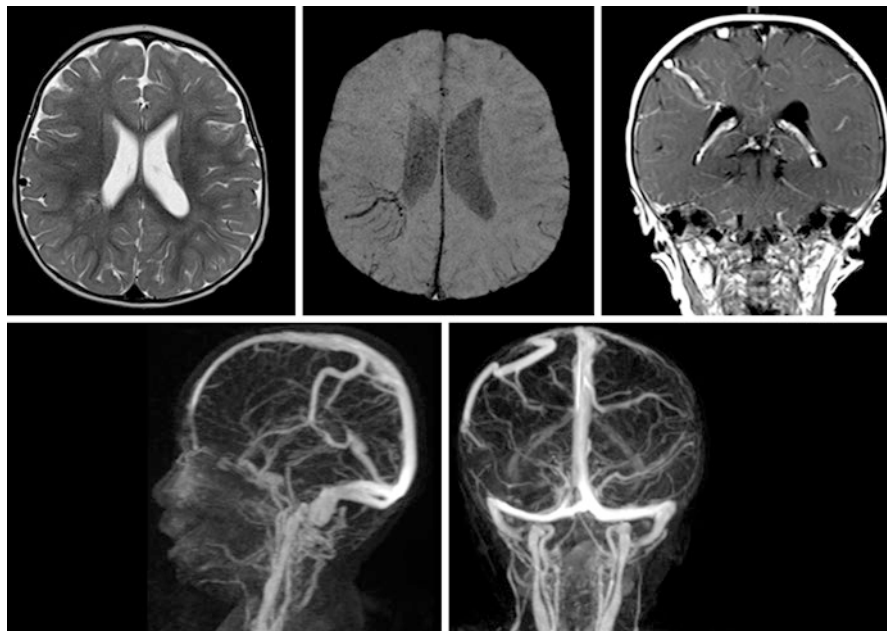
Two-year-old girl with a large right parietal DVA. The DVA is faintly visible on the T2-weighted MR images, well seen on SWI with display of the hypointense caput medusae of veins that converge to the draining collector vein, and prominently enhancing on the T1-weighted coronal MR image. The DVA is also well seen on the contrast enhanced sagittal and coronal MRV. The DVA is draining into the superficial venous system
